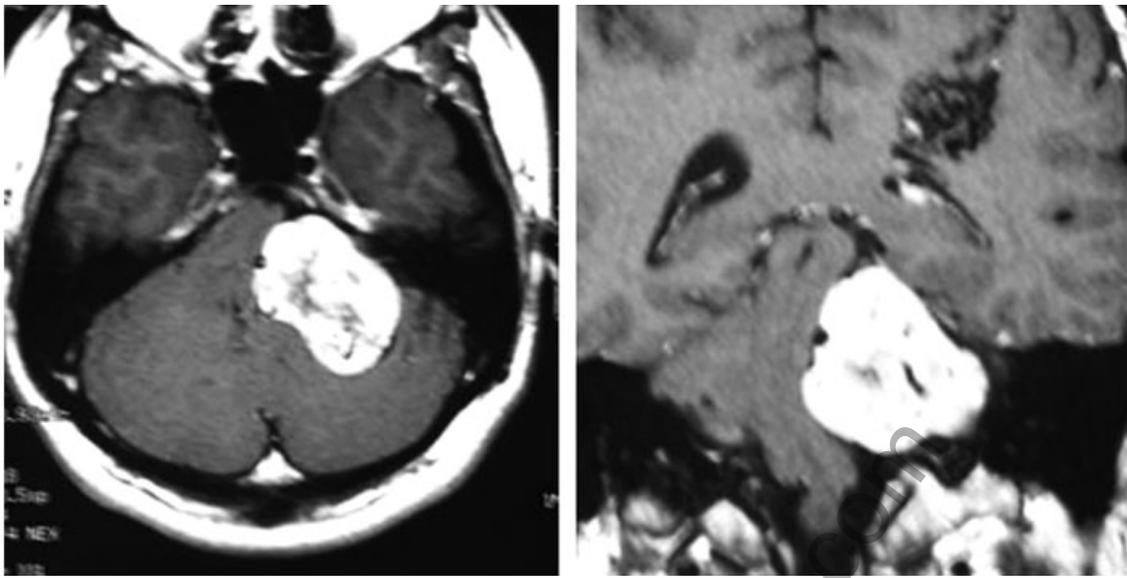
Axial CT (A) and Coronal T1W MRI (B) with contrast showing a left-sided cerebellopontine angle causing brainstem compression, at the time of initial presentation (1997).
